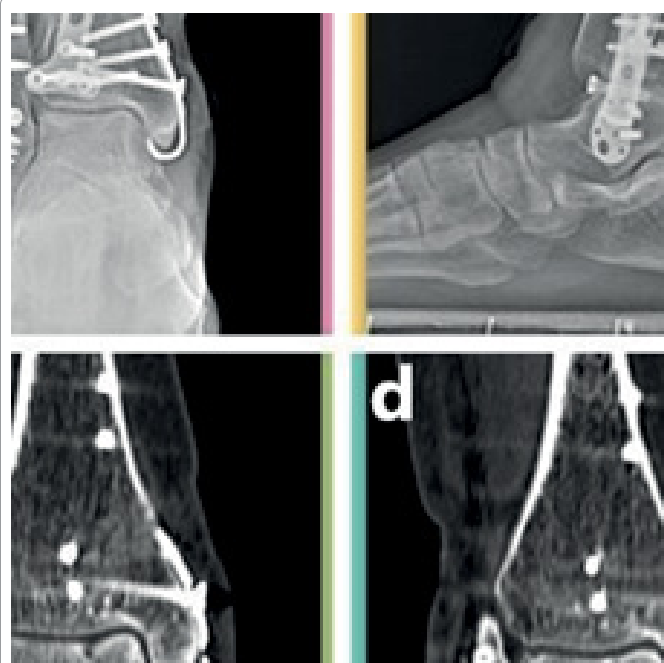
Postoperative X-rays of the same patient. (a) and (b) is the X-ray of post-op at 3 days.
